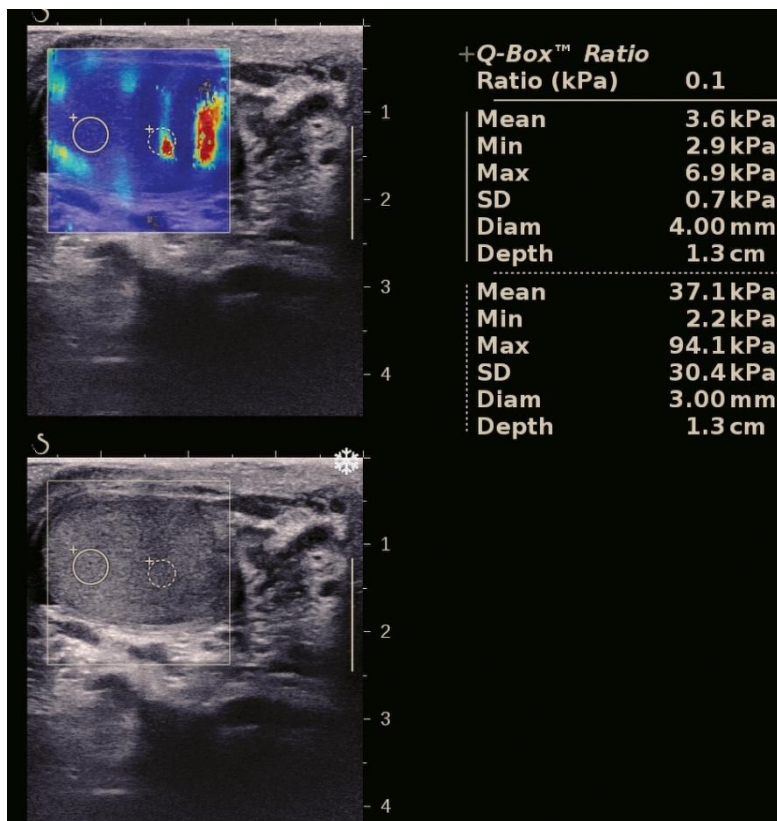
ITS, 2DSWE examination. The gray-scale image (bottom) shows the hypotrophic, inhomogeneous testis with slightly reduced echogenicity in the lower half. 2DSWE (top) reveals increased inhomogeneity and stiffness in the infarcted area compared with the normal upper pole. Contrast-enhanced Doppler and MRI examinations confirmed chronic STI.
